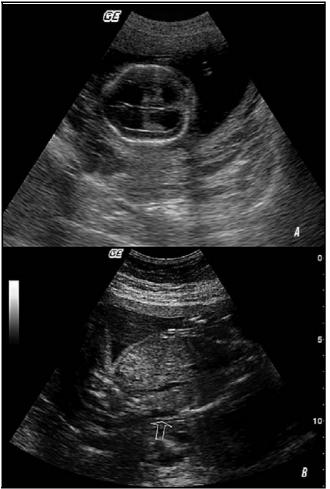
Ultrasonographic finding of Arnold Chian (Chian II) malformation A: Ventriculomegaly, lemon sign B: Spina bifida located in the lumbar region.
